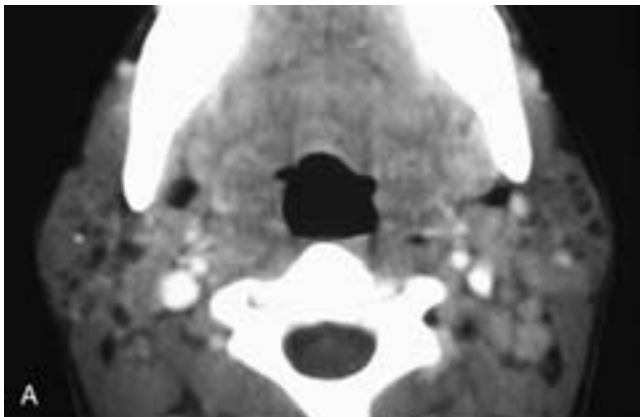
Axial contrast-enhanced CT scans through the parotid glands (A) and the submandibular glands (B and C) show multiple cysts in all of the glands. There is also bilateral adenopathy in the neck. This patient was HIV positive.
